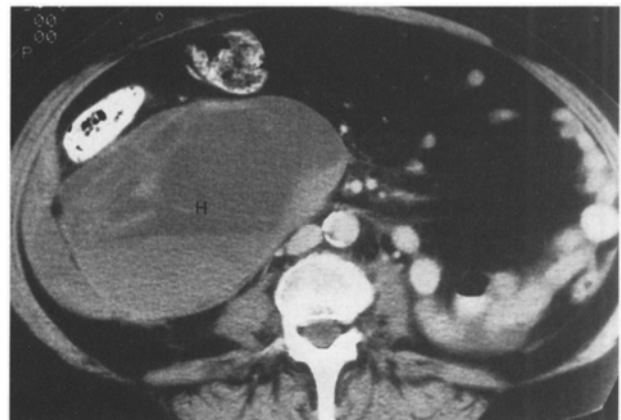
CT with contrast section through the abdomen below level of the kidney showing hematoma with areas of high-density fluid (H) in the retroperitoneal space anterolateral to the inferior vena cava, consistent with fresh blood.
